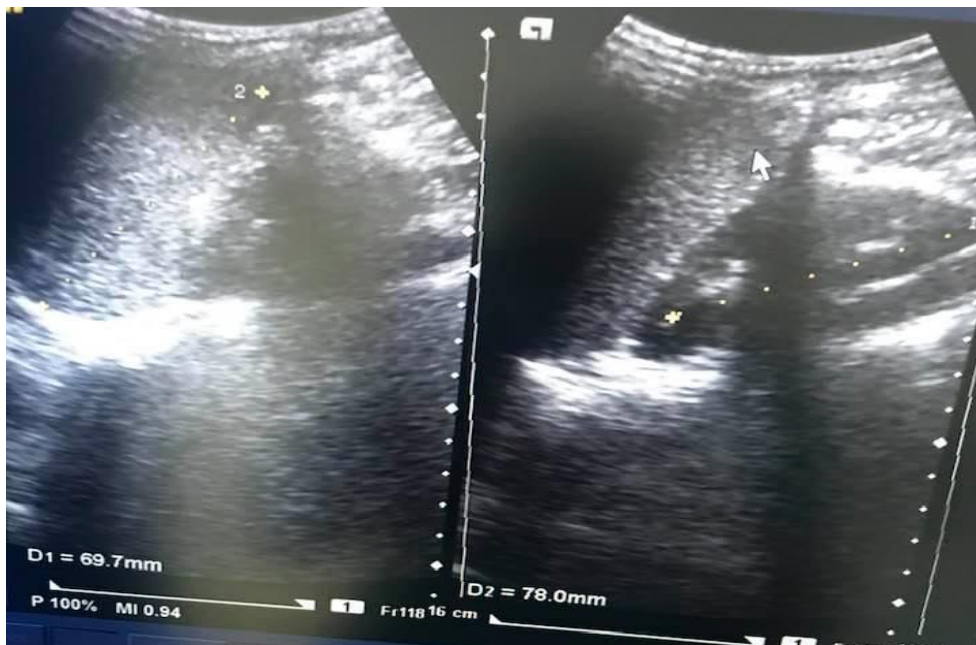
Sonogram of left kidney and spleen lengths of 9year male child
